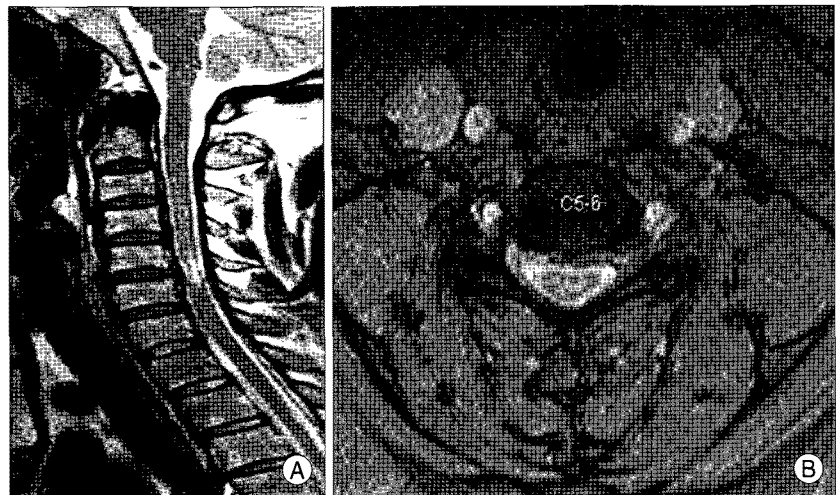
This is cervical magnetic resonance image which was taken at symptom attack. A : Sagittal T1/T2WI show the non-compressive lesion of the spinal cord with signal change on C5/6 interspace. B : Axial T1/T2WI show no severe compression of spinal cord by protrusion of disc.
